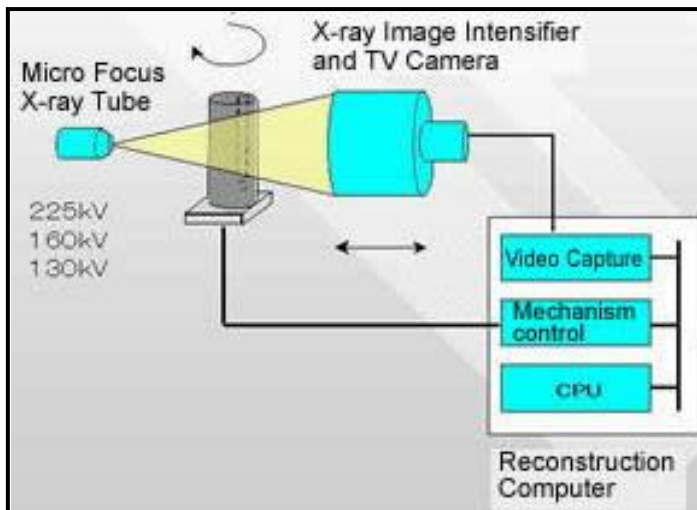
Basic principle of the micro CT
